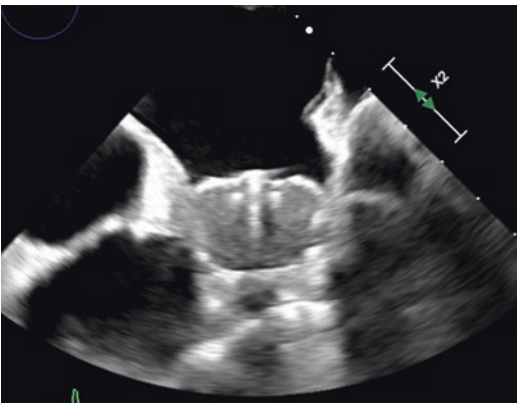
Visualization of an occlusion device within the left atrial appendage by transesophageal echocardiography
